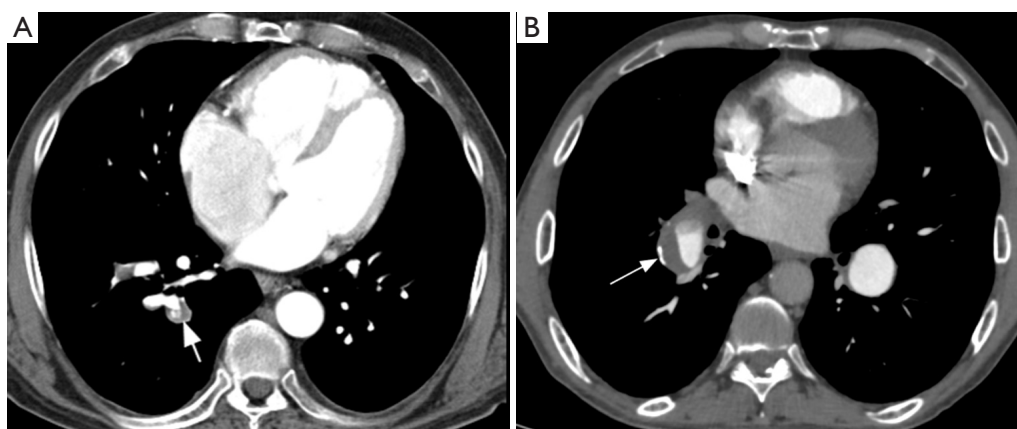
CT pulmonary angiography images in partially occlusive chronic pulmonary embolism. Note peripheral crescent-shaped defects presenting an obtuse angle with vessel wall (arrows in A and B) in contrast with acute angle observed in acute embolism (*Figure 13*).
